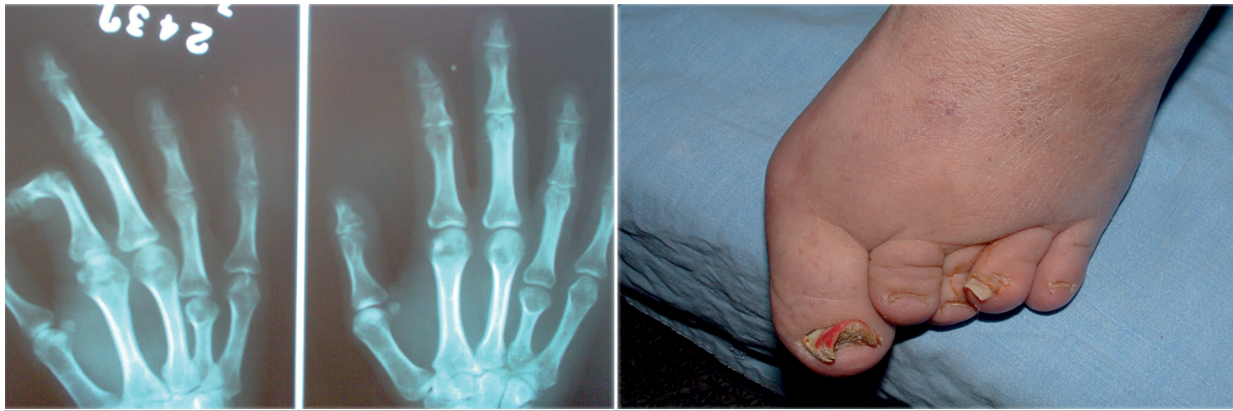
X-ray image of the hand and anomalies, patient T.A.K.: Bilateral shortening of fourth metacarpal. Several anomalies were observed in the toes
